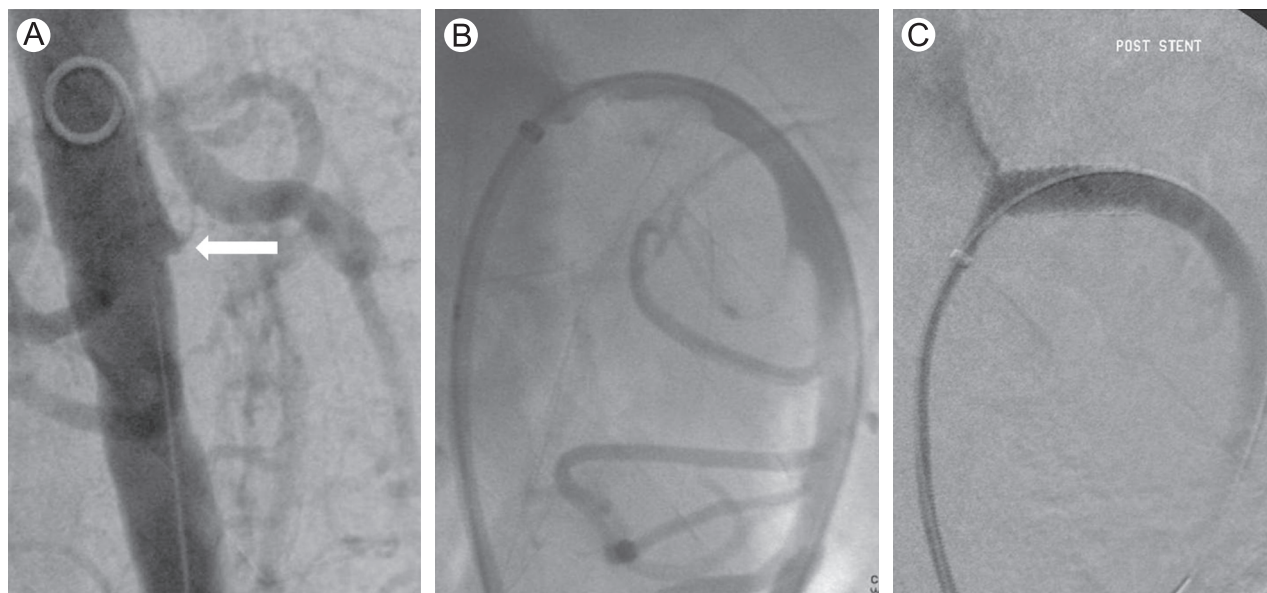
A 78-year-old patient with 2-week history of worsening abdominal pain and occluded SMA on CTA presented for evaluation. (A) Nonselective lateral aortogram demonstrates occlusion of the SMA near the ostium (arrow). (B) A hydrophilic guidewire and reverse-curve catheter was used to cross the occlusion. A sheath was unable to cross the lesion. Following predilation with a balloon of 4×20 mm, a sheath was able to be placed. The sheath was withdrawn, and a contrast injection demonstrated focal narrowing (arrow), which is still seen at the proximal aspect of this vessel, likely secondary to atherosclerotic disease. (C) A balloon-expandable bare metal stent of 6×18 mm is positioned within the proximal SMA. After stent deployment, the SMA is patent, with good flow, as seen on the lateral view.
